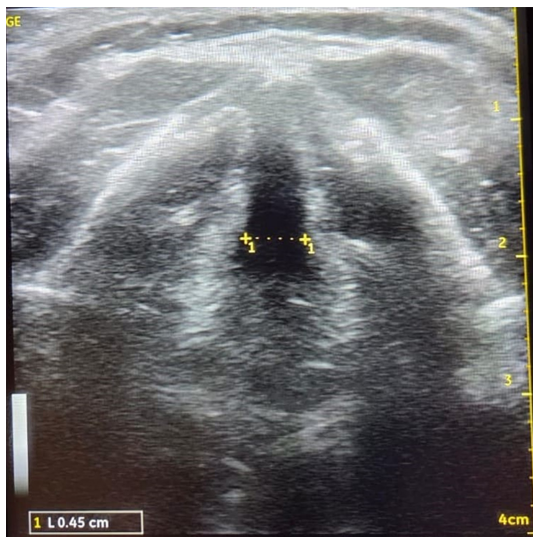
Ultrasound image of the glottis, distance between vocal cords 0.45 cm.
